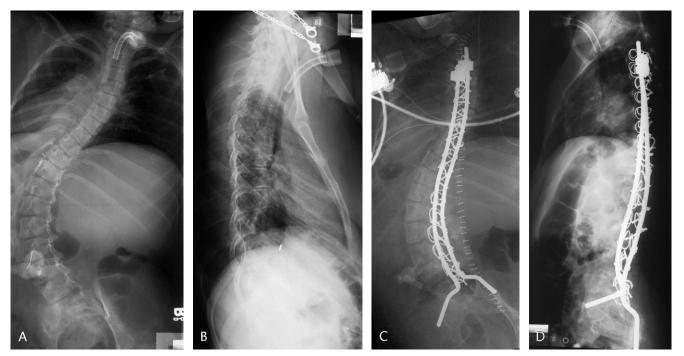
Preoperative and postoperative posteroanterior and lateral radiographs of the second patient with scoliosis.
